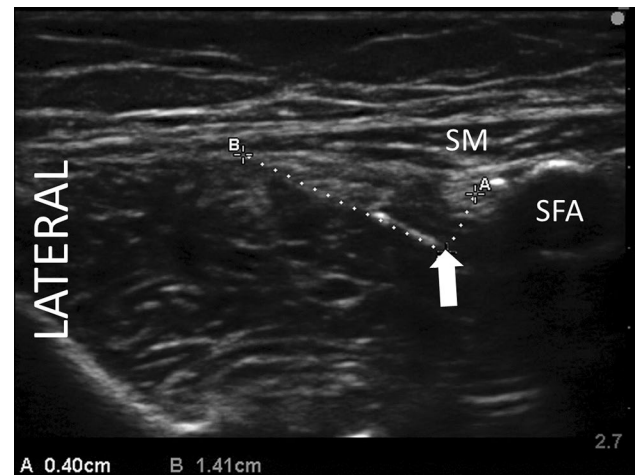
Sample ultrasound image collected during the study demonstrating the sartorius muscle (SM), superficial femoral artery (SFA), catheter tip (white arrow), center of the target nerve (A), and intersection of the catheter and sartorius fascial plane (B); catheter tip (white arrow) to nerve (A) distance and catheter length within the adductor canal (white arrow to B) were measured in (cm) using the caliper function on the ultrasound machine (Edge, Fujifilm SonoSite, Bothell, WA)
